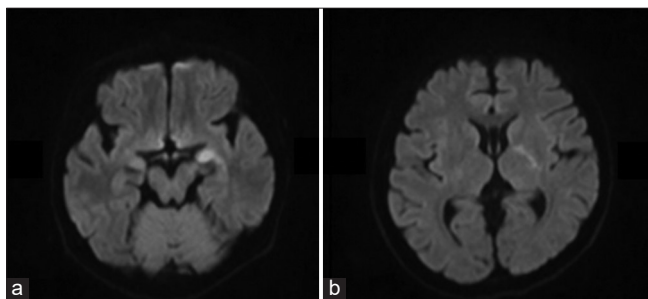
Initial diffusion-weighted magnetic resonance imaging showing acute ischemic infarcts in the territory of the left anterior choroidal artery.
